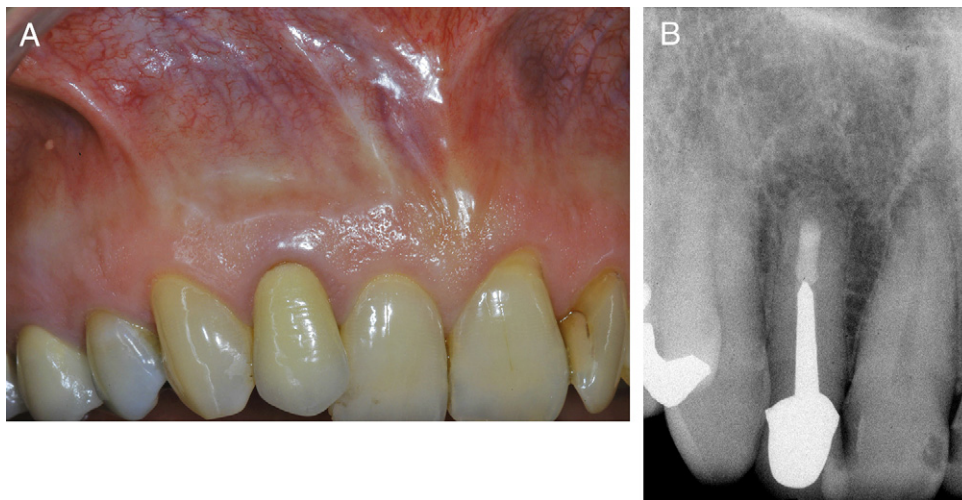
(A) The 5-year clinical examination shows normal and healthy tissues. (B) The 5-year radiograph exhibits complete healing of the previous periapical radiolucency.
